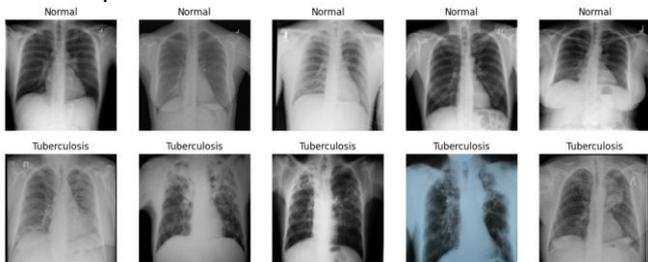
shows sample images of TB-positive and normal chest X-ray.
